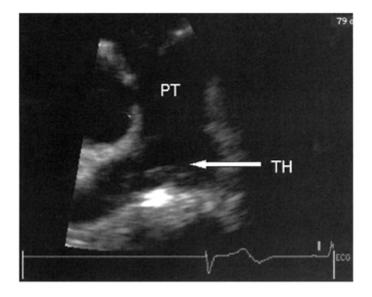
Saddle thromboembolus (TH) lodged in main pulmonary trunk (PT) and extending into both main left and main right pulmonary arteries, as visible from modified short-axis parasternal view. (Reproduced from Echocardiography. Hoffman P, Kasprzak JD (eds). Gdansk: ViaMedica, 2004.)
